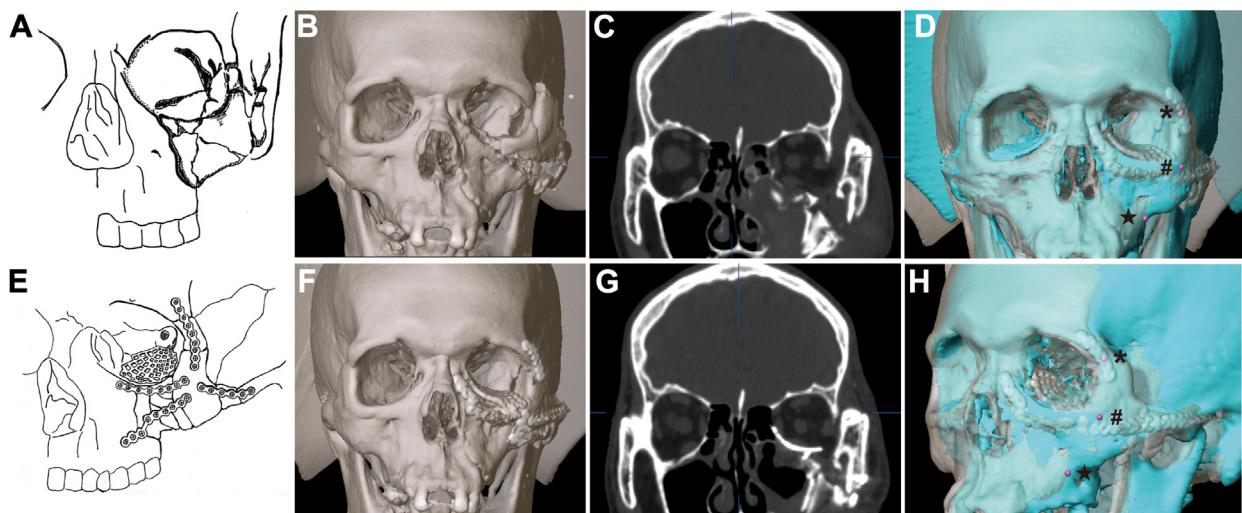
(A, E) Pictorial depiction of ZMC-C fracture and repairment of ZMC-C fracture concurrent with orbital reconstruction. Preoperative (B, C) and postoperative (F, G) computed tomography images of a patient who underwent reduction of left ZMC-C fracture concurrent with orbital reconstruction. (D, H) Anatomical landmarks of the zygoma indicated in the postoperative model. asterisk the midpoint of the fracture line at the zygomatic frontal suture. hashtag the most prominent point on the surface of zygoma. star the intersection point of the zygomatic alveolar buttress and fracture line. ZMC-C, comminuted zygomaticomaxillary complex.
